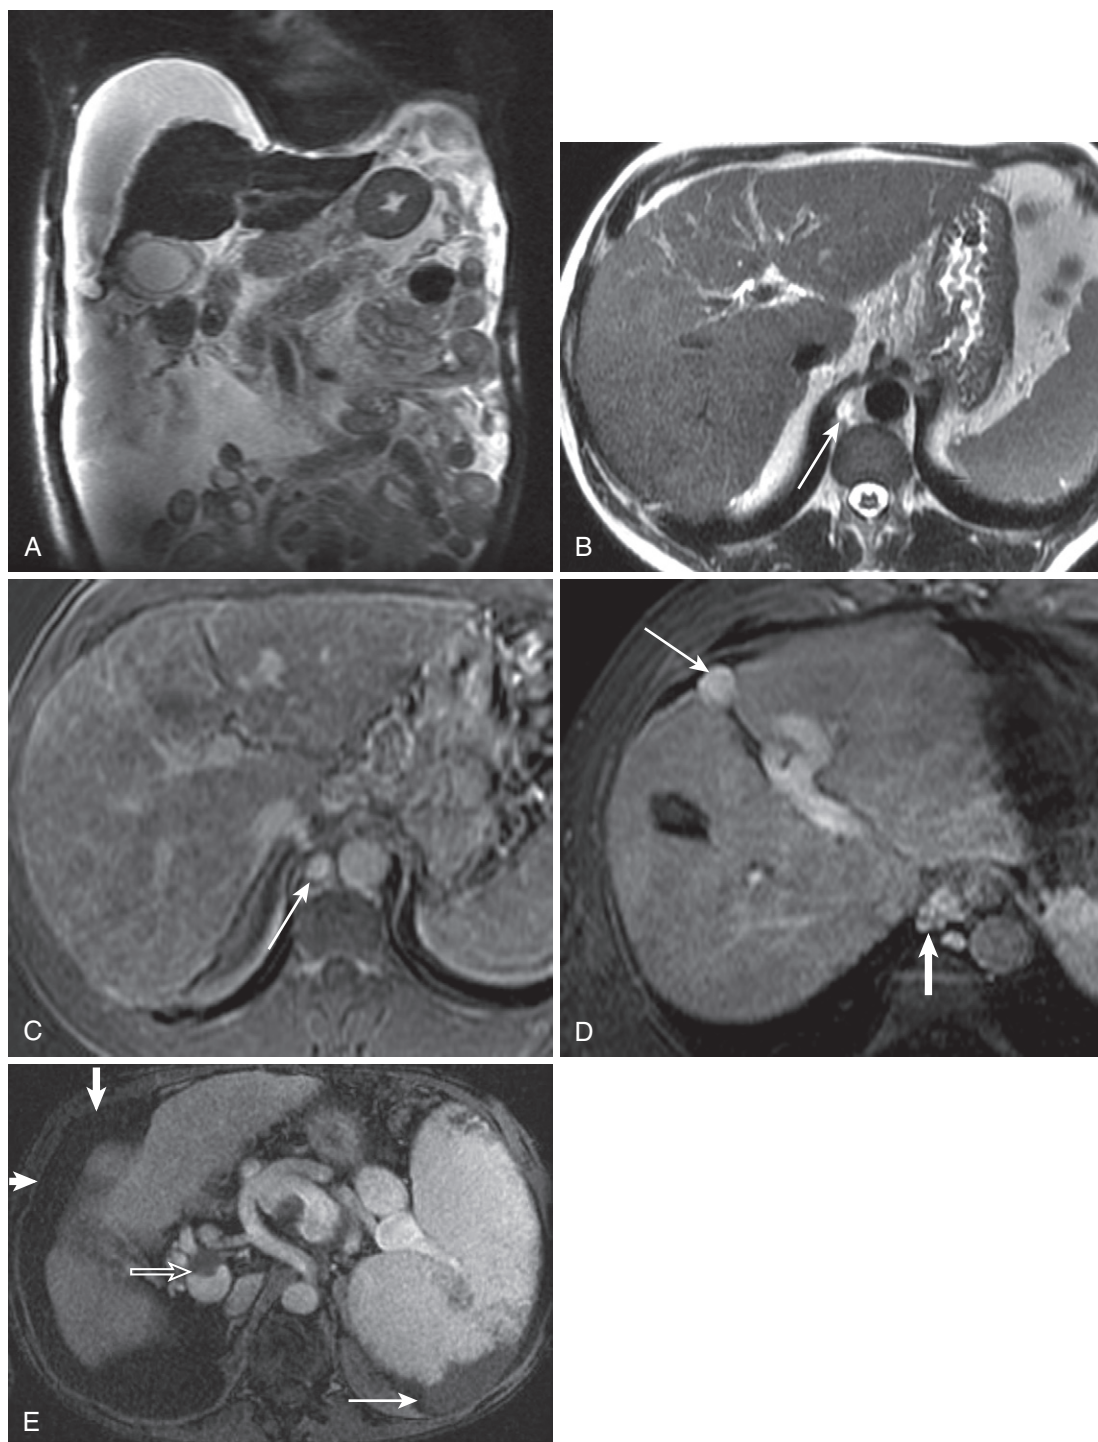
Signs of portal hypertension. A, Coronal heavily T2-weighted image shows the extent of marked generalized ascites and a cirrhotic liver. The axial T2-weighted image (B) at the level of the aortic hiatus shows a hyperintense fluid-filled structure (*arrow* in B and C), which enhances on the delayed image (C), characteristic of a lymphatic structure and in the expected location of the cisterna chyli—in this case, enlarged due to portal hypertension. D, Delayed postcontrast image in a different patient with portal hypertension reveals portosystemic collateral channels, including a large paraumbilical portosystemic collateral vessel (*thin arrow*) and paraesophageal varices (*thick arrow*). E, A different patient with cirrhosis exemplifies features of portal hypertension—splenomegaly with a splenic infarct (*thin arrow*), ascites (*thick arrows*), and nonocclusive portal venous thrombus (*open arrow*).
